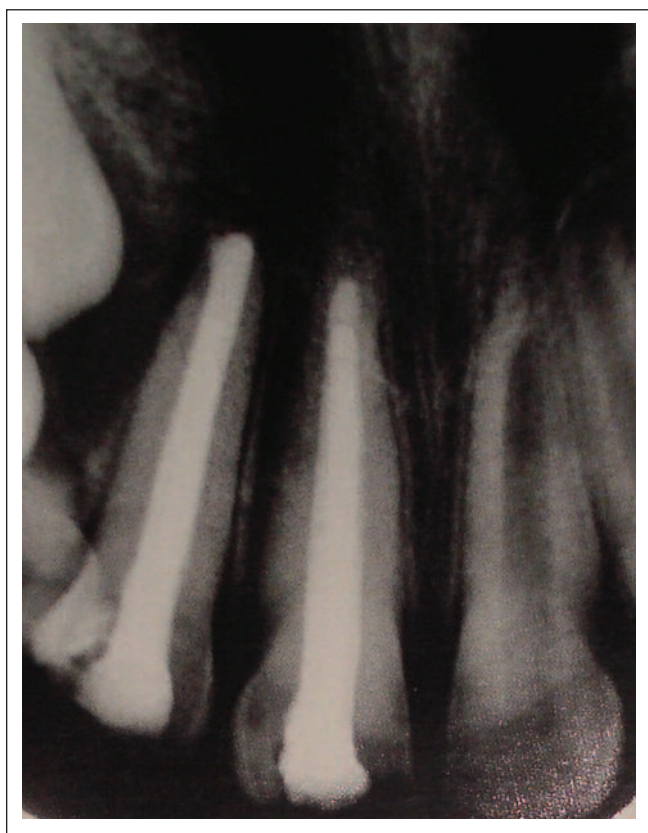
Obturation of Maxillary (Rt) Lateral Incisor (Calcium Hydroxide) following radiographic evidence of calcific barrier.
